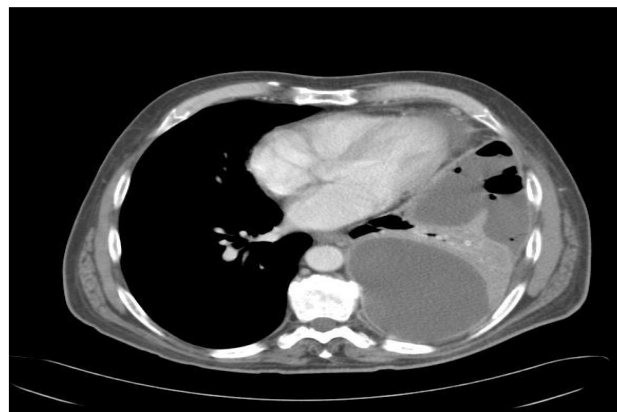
Chest computed tomography: left-sided hemothorax.
